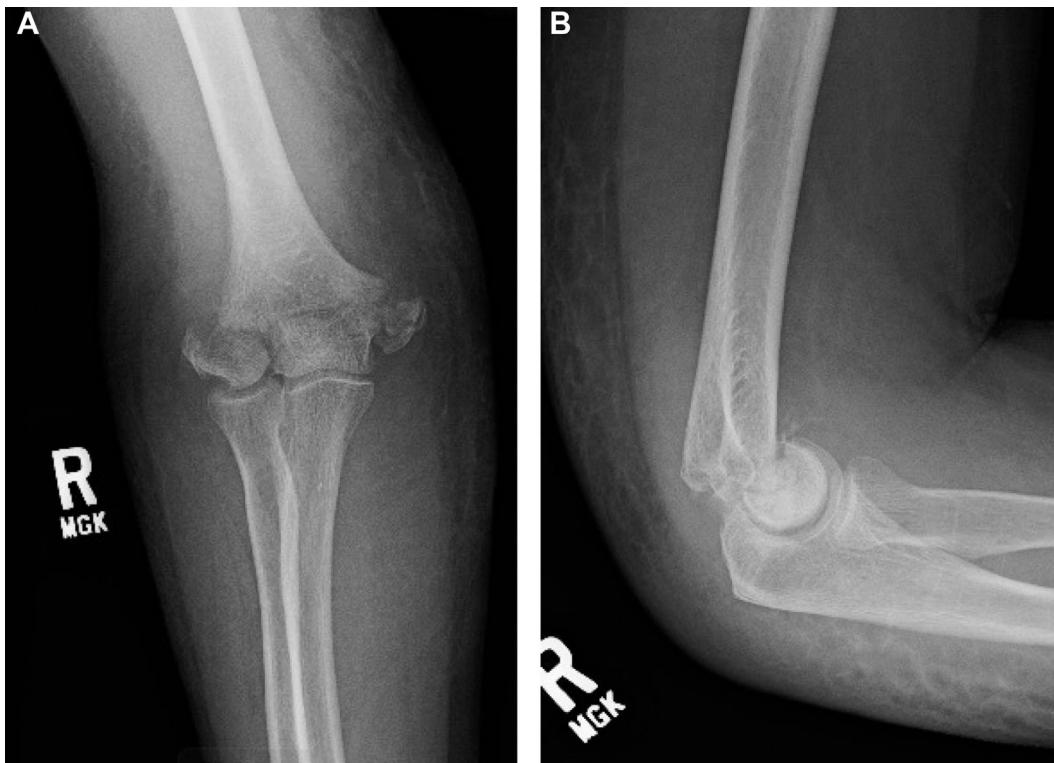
Case 2: A 59-year-old woman who presented 6 days after a fall on ice, in which she sustained a right elbow injury. The radiograph revealed a right distal humerus intraarticular fracture (see Fig. 4) and right distal radius fracture (see Fig. 5). She underwent distal humerus ORIF with dual plating and olecranon osteotomy (see Fig. 6) and distal radius ORIF (see Fig. 7). She had an anterior subcutaneous transposition of the ulnar nerve but required a transfer of her anterior interosseous nerve to her right ulnar motor nerve for ulnar neuropathy.
